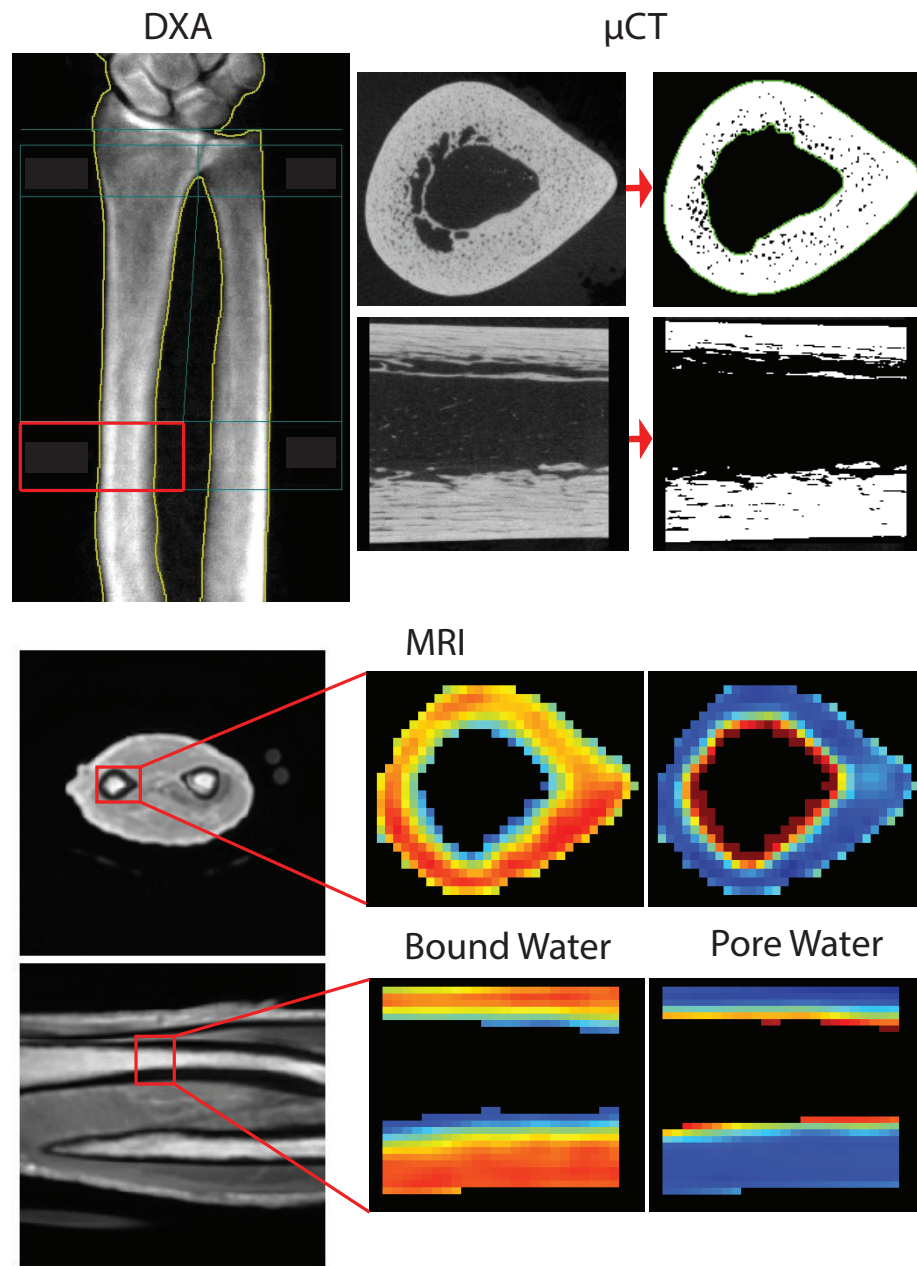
The imaging modalities used on one representative radius, all analyzed at the same distal third section (shown in the red boxes). The top left shows the DXA scan, where the blue lines show how the aBMD is typically found in a clinical setting. The red box shows the distal-third section from which the aBMD was used in this study. The top right shows the μ CT scan of the distal-third section of the radius in two planes with thresholded bone. The bottom images show a conventional UTE MRI scan in two planes with corresponding C_{pw} and C_{bw} maps. .
